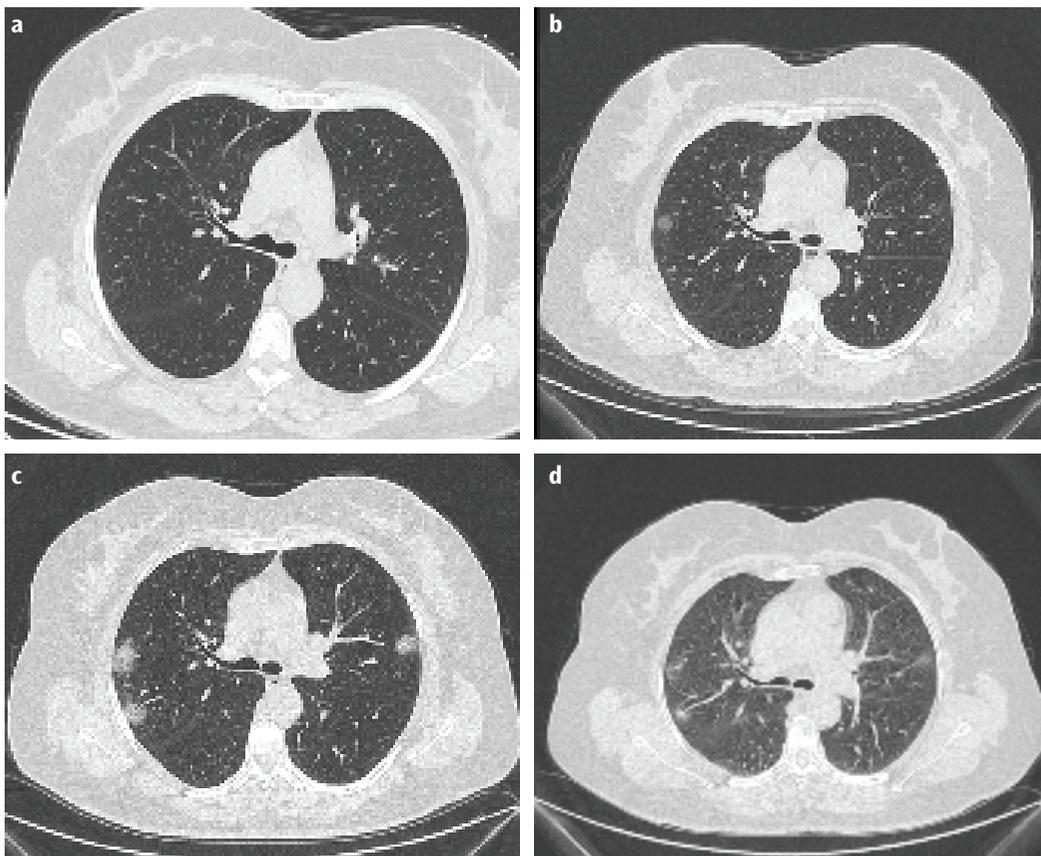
a-d. CT scans in a 48-year-old woman with coronavirus 2019 pneumonia. Axial CT image (a) obtained 3 days after the onset of initial symptoms (stage-1) shows no abnormal findings . Axial CT image (b) obtained 7 days after the onset of initial symptoms (stage-2) shows a round and patchy GGO around the subpleural area of right upper lobe. Axial CT image (c) obtained 12 days after the onset of initial symptoms (stage-3) shows crazy-paving pattern appear within the GGOs with increased extent, GGO and crazy-paving pattern also appeared in the left upper lobe. Axial CT image (d) obtained 34 days after the onset of initial symptoms (stage-6) shows small residual GGOs in both upper lobes
